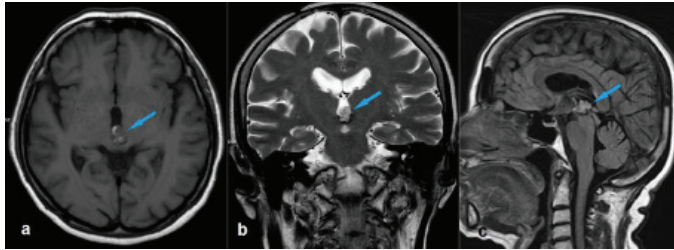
Axial T1-weighted (a), coronal T2-weighted (b) and sagittal FLAIR (c) images demonstrating a well-defined lobulated mass in the interpeduncular cistern (arrows). Note the lesion protrudes into the third ventricle (c)
